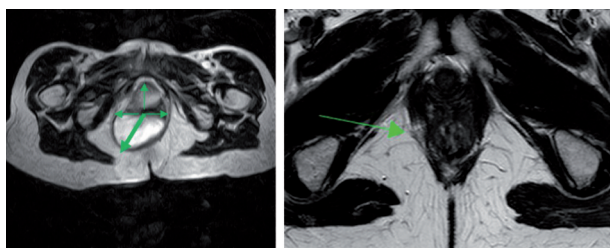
(A) Asymmetric ballooning of levator hiatus on Valsalva reflecting the different capacity of its peripheral boundaries to counteract the radial forces from inside the abdomen in a similar way (arrows of different length). (B) A fibrofatty focal defect (arrow) was found in the right pubococcygeal muscle on the corresponding axial T2-weighted static sequence.
